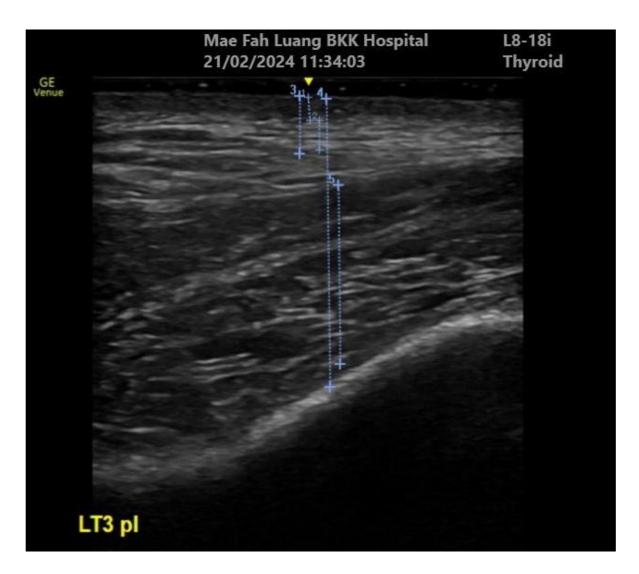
Temporal soft tissue layers for ultrasound assessment, with depth measurements: 1 = D1, 2 = D2, 3 = D3, 4 = D4, and 5 = D5.
